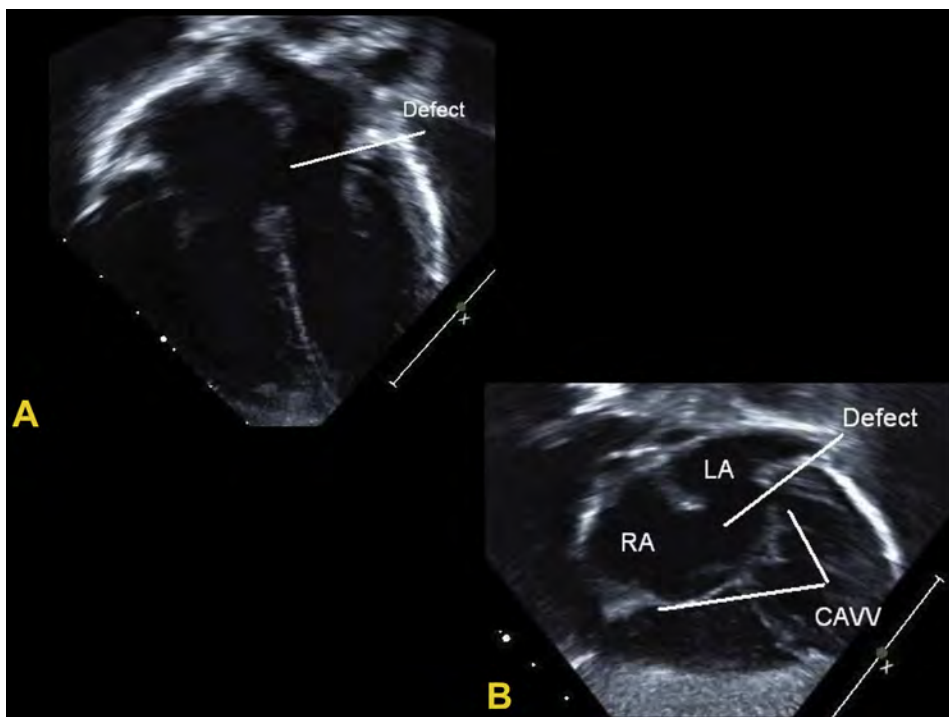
(A) Primum ASD by 2D TTE in apical four-chamber view. (B) Primum ASD by 2D TTE in subcostal left anterior oblique view. CAVV, common AV valve.
